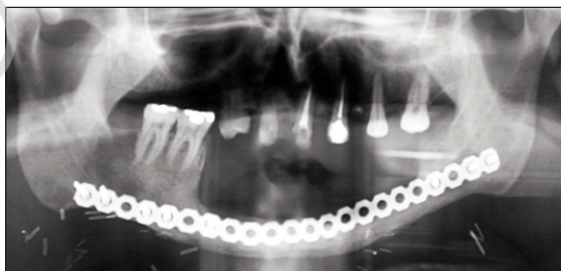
Orthopantomography post-resection.
